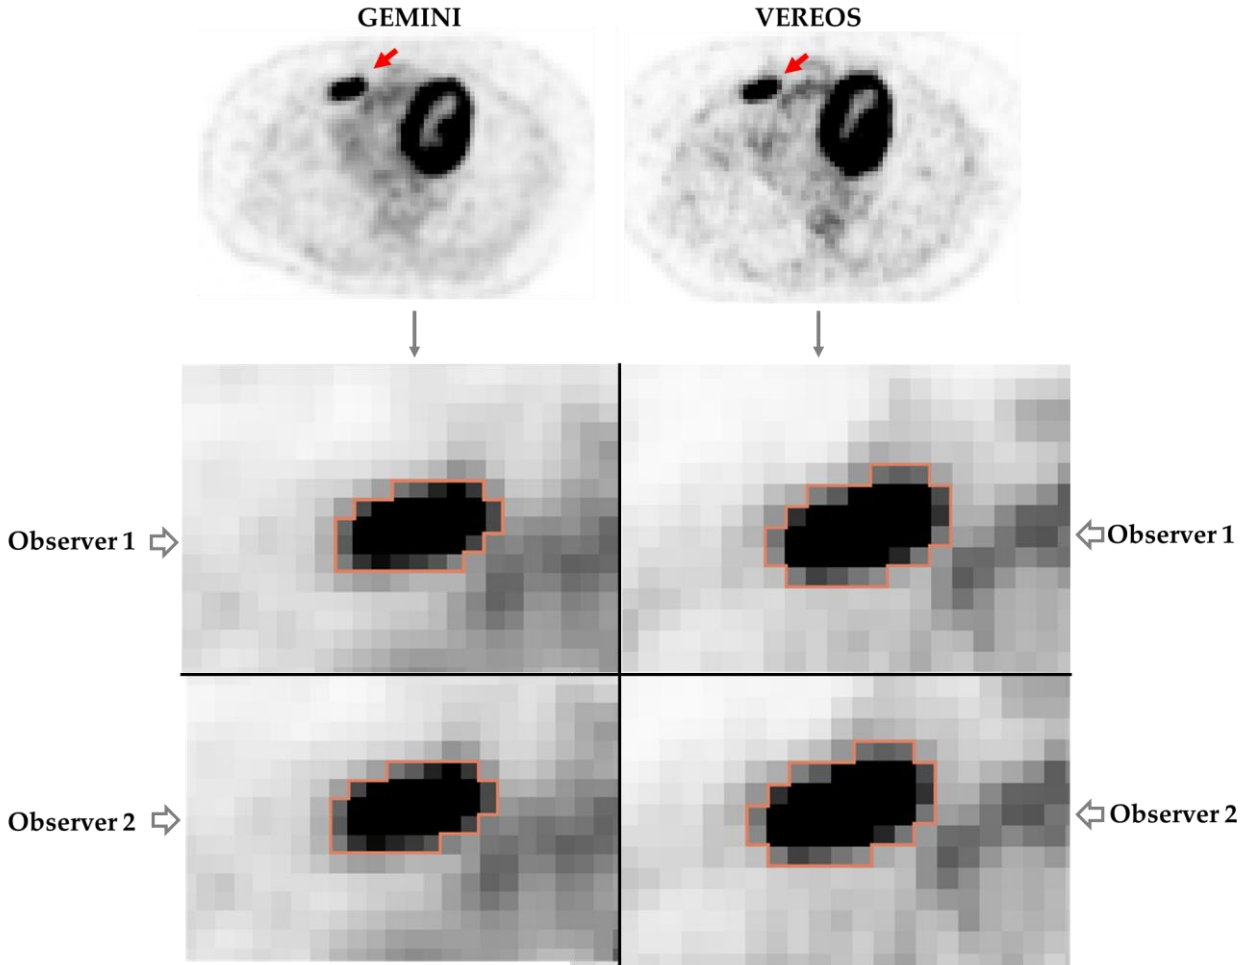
Manual segmentation by two observers in the same lesions in images acquired by VEREOS and GEMINI scanners. The lesions to delineate manually are identified by a red arrow in the original PET/CT images. Each manual segmentation is represented by a rosy contour.
